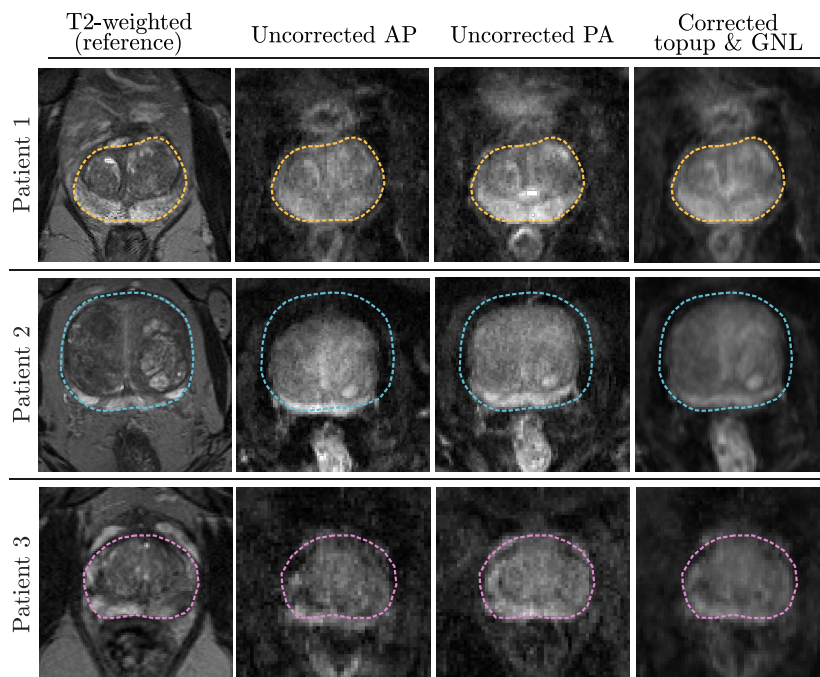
Visualisation of the distortion correction processing steps applied to the acquired data: Patient 1 - ideally positioned at isocentre, Patient 2 - positioned offcentre, Patient 3 - positioned at isocentre, with perceptually more severe distortions. The reference T2-weighted images with prostate gland delineation (*dashed lines*) are shown, alongside with AP and PA phase encoded $b = 0 \text{ ms}/\mu\text{m}^2$ image from dMRI EPI scans. The result of the applied corrections is shown in the last column.
